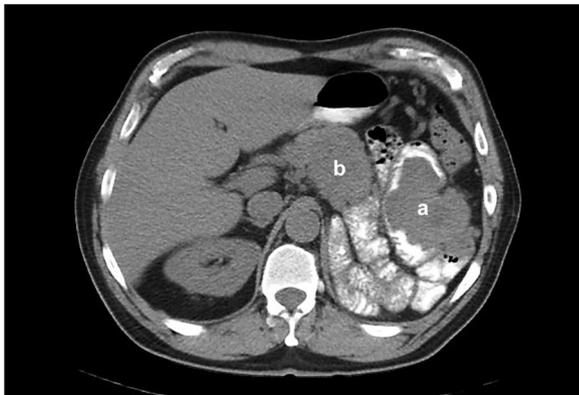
Axial view of the abdominal CT with oral contrast showing the left renal fossa occupied by small bowel segments (a), as well as a hyperdense lesion, infiltrating the intestinal segments and gastric wall (b).
